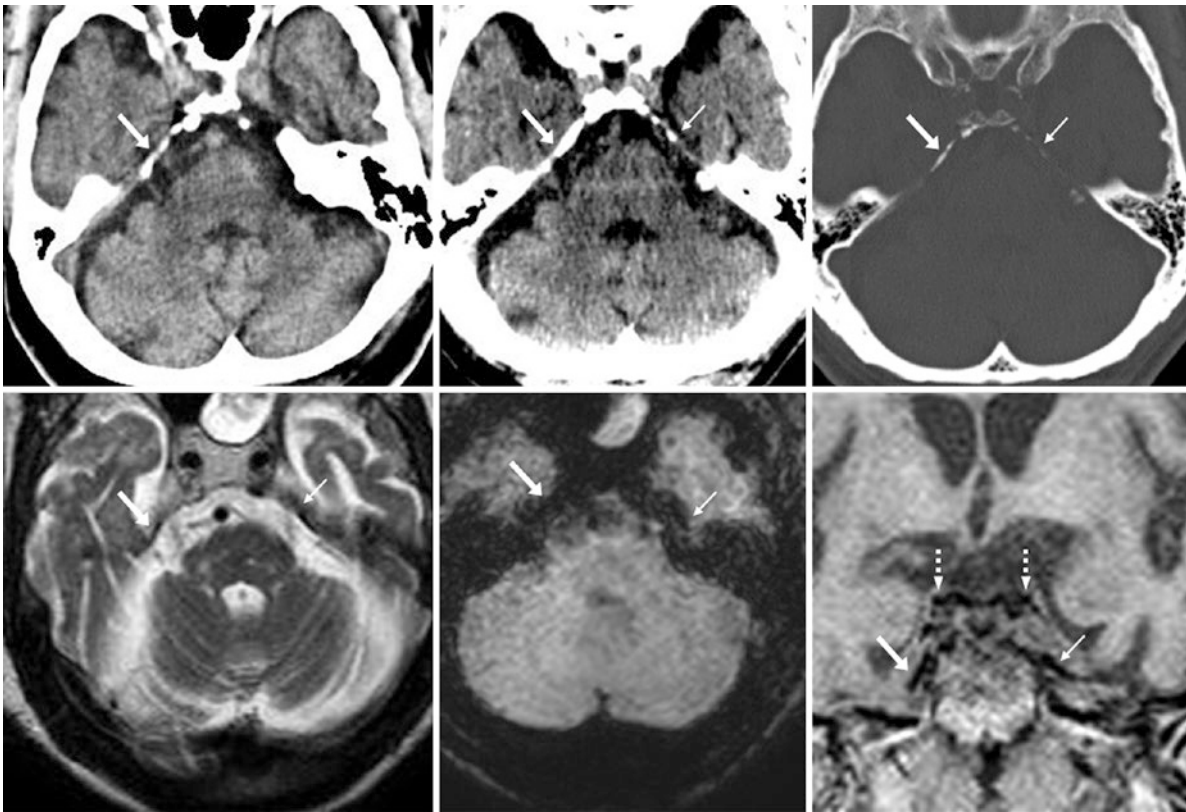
An 81 year old with a calcified right PCL on NECT (*top left*), which had further calcified on a NECT 7 years later (*top middle*, with bone windows at *top right*); the left PCL had also further calcified (*thin arrows*). The calcifications are not visualized on T2WI MRI (*bottom left*), while on SWI (*bottom middle*), artifact from gas within the mastoids obscured the PCLs. On coronal GE T1WI (*bottom right*), the posterior clinoids (*dashed arrows*) are also depicted
